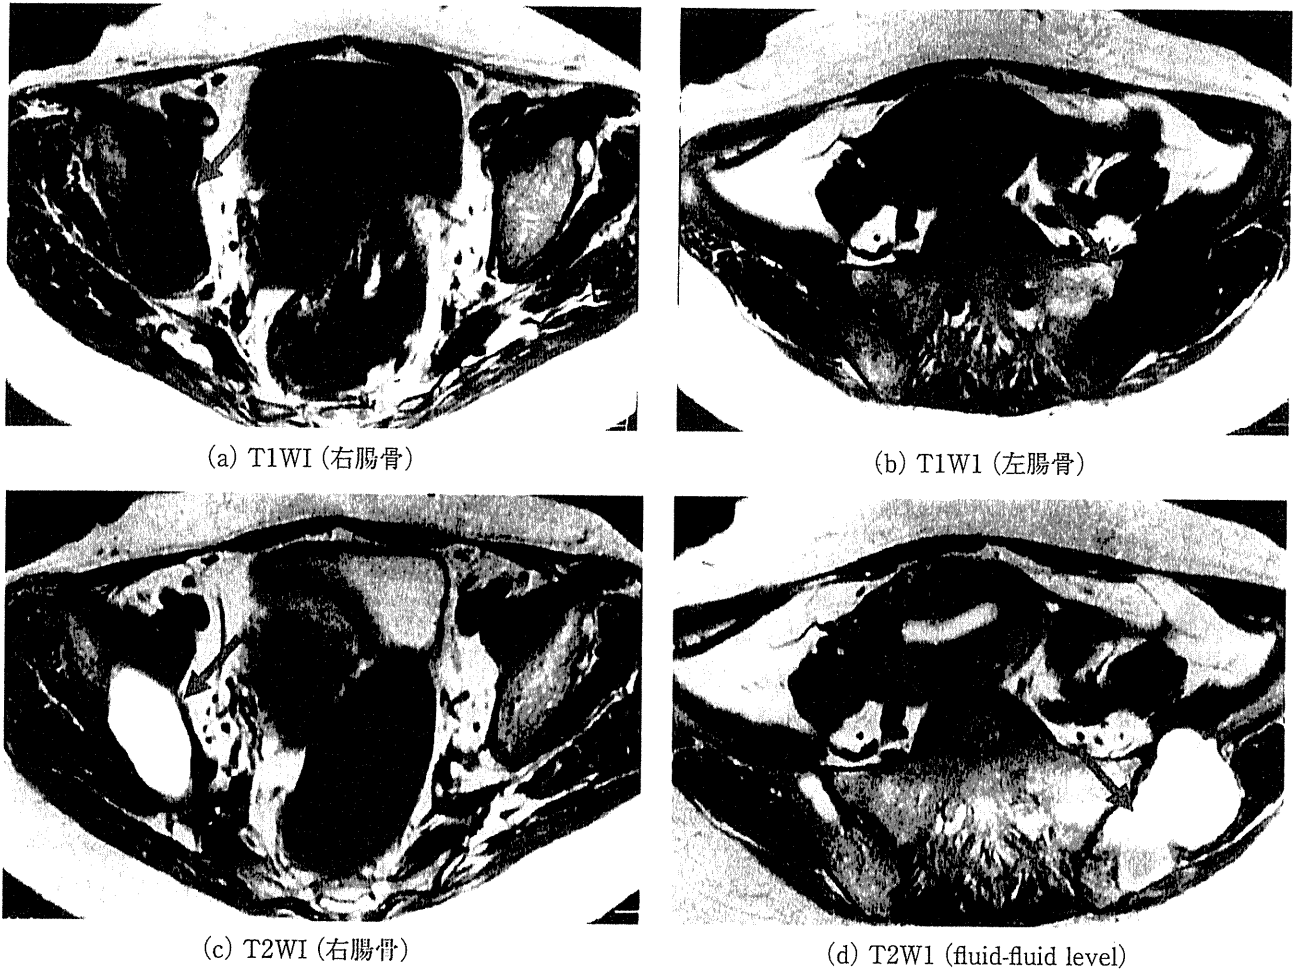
MRI. 右腸骨臼蓋部および左腸骨部仙腸関節近傍にそれぞれ長径約 7 cm 大の腫瘍性病変を認める。腫瘍は周囲に膨隆し、内部は T1 強調画像で低信号、T2 強調画像で高信号を呈する。また、左側の病変は内部に T2 強調画像で fluid-fluid level の形成を認める (左右ともに矢印で示した)。
